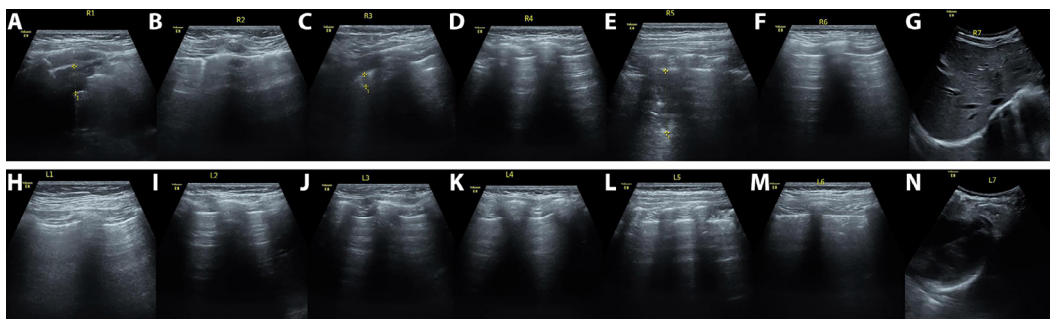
Fourteen-zone ultrasound images of the lungs of a 6-year-old male child with mycoplasma pneumonia. A: pleural line abnormalities with extensive (>1 cm depth) pulmonary solid lesions in the right upper anterior region; B: scattered, non-confluent B-lines are seen in the right anterior-inferior region; C: pleural line abnormalities with small (<1 cm depth) subpleural pulmonary solid lesions in the right supra-axillary region; D: A line predominance with sporadic (<3) B-lines in the right infra-axillary region; E: right posterior upper zone see pleural line abnormalities with extensive (>1 cm depth) pulmonary solid lesions; F: right posterior inferior zone see predominantly A-lines, see scattered (<3) B lines; G: right lung base zone see scattered, non-confluent B-lines; H: left anterior upper zone showing scattered, non-confluent B-lines; I: left anterior inferior zone showing predominantly A-lines with scattered (<3) B-lines; J: left axillary upper zone showing predominantly A-lines with scattered (<3) B-lines; K: left axillary region showing predominantly A-lines with sporadic (<3) B-lines; L:left posterior superior region showing predominantly A-lines with sporadic (<3) B-lines; M: left posterior inferior region showing predominantly A-lines with sporadic (<3) B-lines; N: left lung base region showing predominantly A-lines with sporadic (<3) B-lines. The combined MLUS for this patient was 17.
